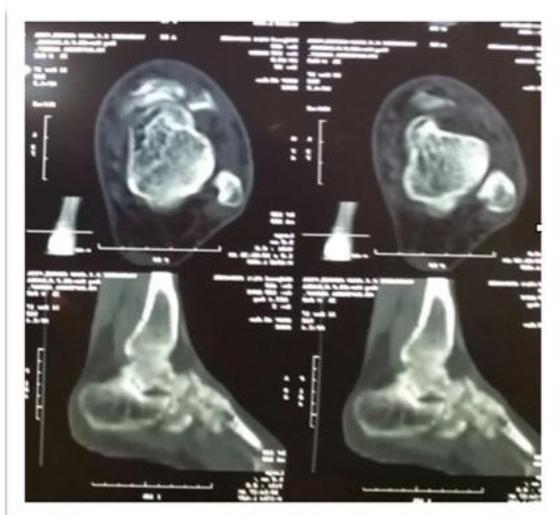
CT Scan Axial And coronal images showing fracture of the navicular bone.
